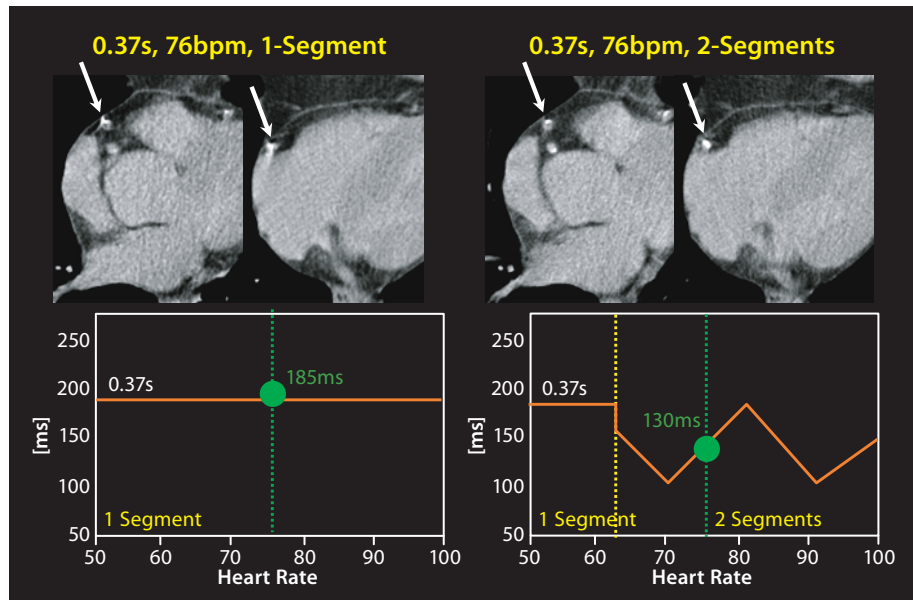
Case example of a 16-slice CT cardiac examination that demonstrates the improvement of image quality with adaptive segmented vs. single-segment reconstruction at higher heart rate. A coronary calcium scan was performed in a patient with 76 bpm during the scan with: 16×1.5 -mm collimation, 0.37-s rotation, reconstruction in diastole at 55% of the RR-interval. Coronary calcifications in the left anterior descending and right coronary arteries (arrows) are depicted with considerably less motion using adaptive-segmented reconstruction (right, $S = 2$ segments, 130-ms temporal resolution) compared to single-segment reconstruction (left, $S = 1$ segment, 185-ms temporal resolution). (Case courtesy of Tübingen University, Germany)
